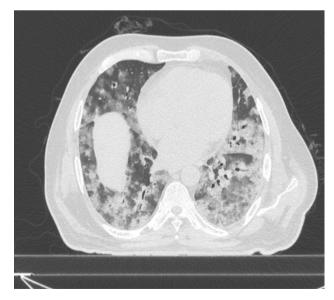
Axial cut of HRCT thorax of patient C showing bilateral extensive ground glassing
